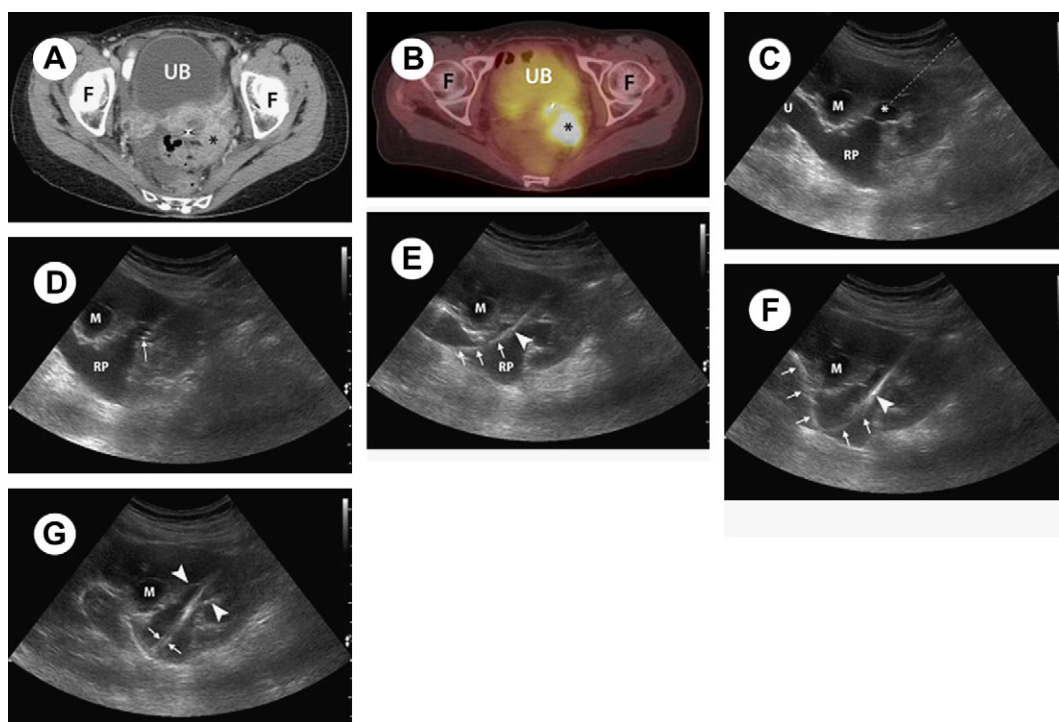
Ultrasound-guided definitive needle access for PCN. (A, B) Axial contrast-enhanced CT image (A) and a positron emission tomography-CT image (B) at the level of the femoral heads (F) of a patient with left pelvic mass (asterisk) obstructing the left ureter in its distal course as it approaches the urinary bladder (UB). The malignant mass takes up radiotracer (asterisk). (C) Gray-scale ultrasound image of the left kidney with the operator centered at the lower pole calyx (asterisk). A dashed line is drawn to show the needle trajectory that is planned. Above the target calyx (asterisk) lies the mid to lower pole calyx (M). The upper pole calyx (U) is observed continuous with the renal pelvis (RP) that lies deep to the mid and lower calyces. (D) Gray-scale ultrasound image of the left kidney of the same patient. The operator has passed an 18-gauge needle (arrow at needle tip) directly into the lower pole calyx. (M indicates mid to lower pole calyx, RP indicates renal pelvis). (E, F) Gray-scale ultrasound image of the left kidney of the same patient. The operator has passed a 0.035-in guidewire (arrows) through the 18-gauge needle (arrowhead at needle tip) that is in the lower pole calyx. At this point of the procedure, fluoroscopy is used as the image-guidance modality. (G) Gray-scale ultrasound image of the left kidney of the same patient. This is an image obtained after the 8F nephrostomy drain (between arrows) has been placed through the lower pole calyx (between arrowheads) and into the RP.
